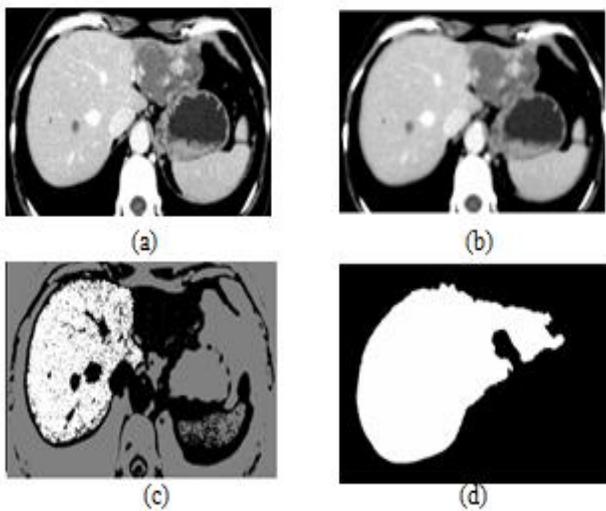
Automatic Liver Extraction from CT images. a) Original image, b) Mean shift filter, c) Adaptive threshold method, d) Extract liver.
